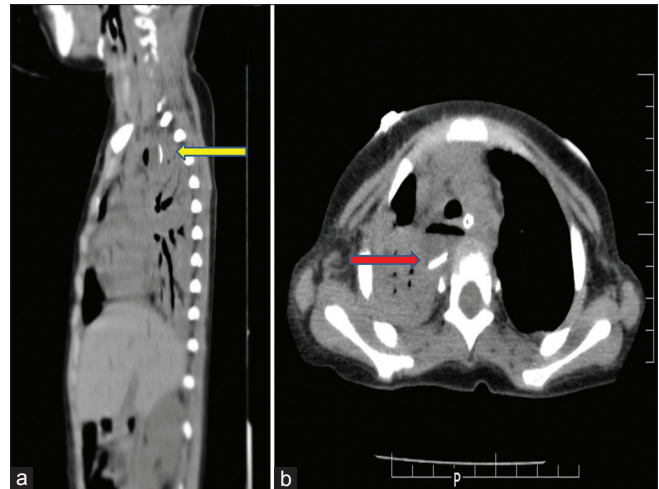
(a) Computed tomography scan thorax - sagittal section - radiopaque foreign body posterior to cricopharynx. (b) Computed tomography scan thorax - transverse section - radiopaque foreign body
